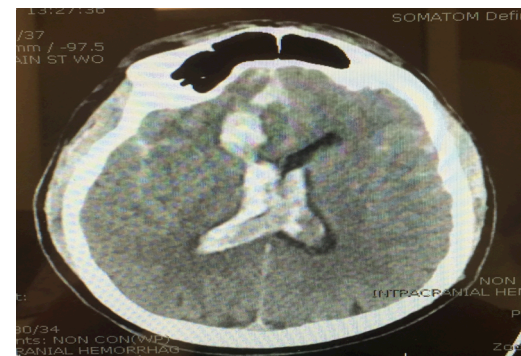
Post intubation CT Brain w/o contrast showing progression of abnormalities and large amount of intraventricular blood.
